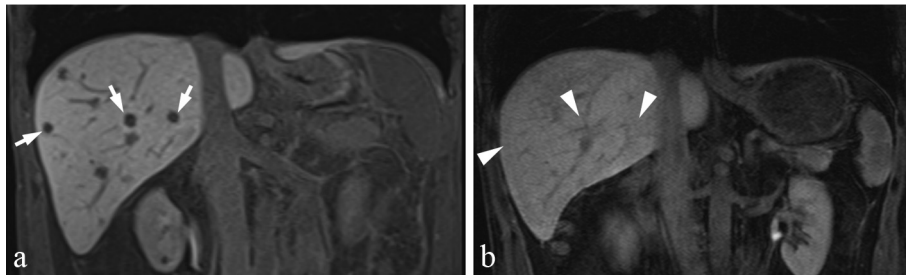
Coronal hepatobiliary 20 min delay MR image at baseline (a) demonstrating colorectal metastases in the liver (arrows). Coronal hepatobiliary 20 min delay MR image at pre-surgical staging (b) demonstrating no lesion at the site of metastases on the prior exam (arrowheads).
